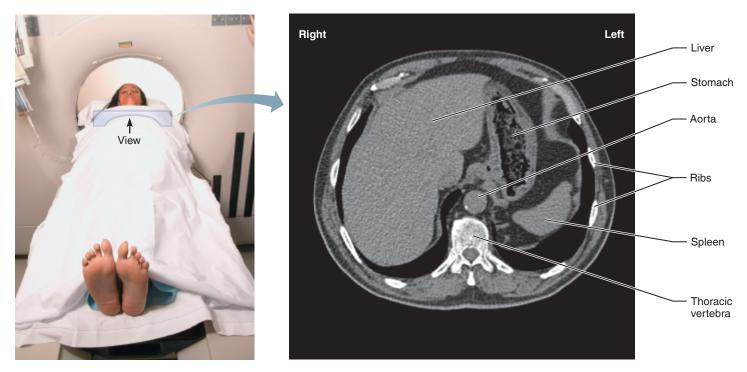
Computed tomography (CT). CT scan through the upper abdomen. CT sections are conventionally oriented as if viewed from an inferior direction, with the posterior surface of the body directed toward the inferior part of the picture; therefore, the patient's right side is at the left side of the picture.
